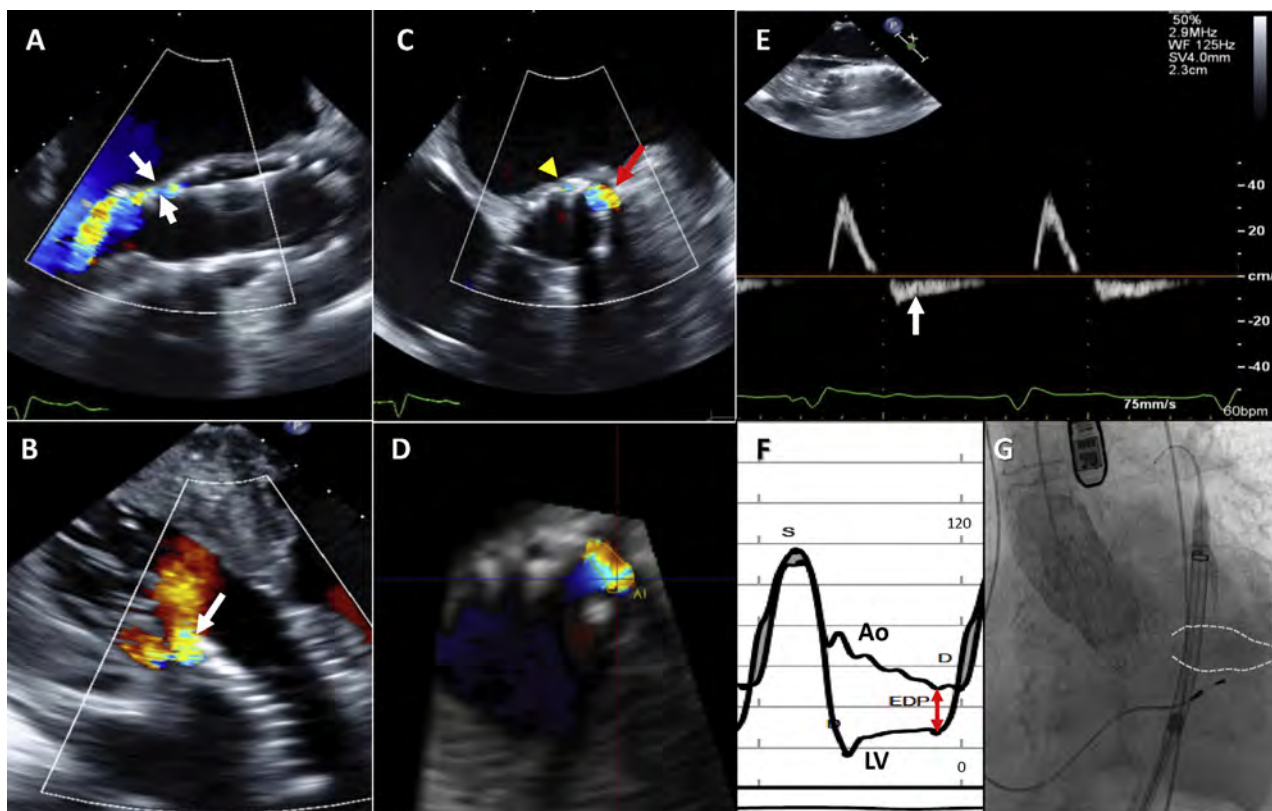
Tools for the intra-procedural assessment of paravalvular regurgitation following TAVR: color Doppler (2D/3D), pulsed-wave Doppler of aortic flow, aortic & LV diastolic pressures and aortography. All panels are from the same patient. The valve is a self-expanding valve. (A) Mid-esophageal TEE long-axis view showing paravalvular AR (*white arrows*). Off-axis imaging is frequently helpful. (B) Deep transgastric view showing the paravalvular jet seen in panel A. Multiple views are essential to avoid missing jets. (C) Mid-esophageal short-axis view showing a paravalvular jet (*red arrow*), and a pinhole jet (*arrow head*). It is important to scan the valve and image at the lower end of the valve stent to ensure that the measured jet reaches the LV. The circumferential extent of the larger jet here is 14% but the jet is relatively wide. The pinhole jet is too small to planimeter. (D) 3D planimetry of the same paravalvular jet yields an area of 0.22 cm². 3D echocardiography makes it possible to precisely identify the vena contracta, something that may be challenging with 2D imaging alone. (E) Mid-esophageal TEE images of the descending thoracic aorta showing non-holodiastolic flow reversal by pulsed-wave Doppler. Some flow reversal, usually non-holodiastolic, may be present in patients undergoing TAVR even in the absence of aortic regurgitation; Hence it is important to establish the baseline aortic flow pattern. (F) Simultaneous LV and aortic (Ao) pressure tracings that form the basis for the AR index. In this case, the AR index is 28%. Indices of <25% have been reported to have increased 1-year mortality. However, this value is very dependent on aortic and ventricular compliances as well as the severity of paravalvular regurgitation. *Red arrow* denotes diastolic BP – LVEDP. (G) Diastolic still frame from post-implantation aortogram showing 2+ paravalvular AR (*outlined area*). Ao, Aortic pressure tracing; EDP, end-diastolic pressure; LV, left ventricular pressure tracing; S, systole.
